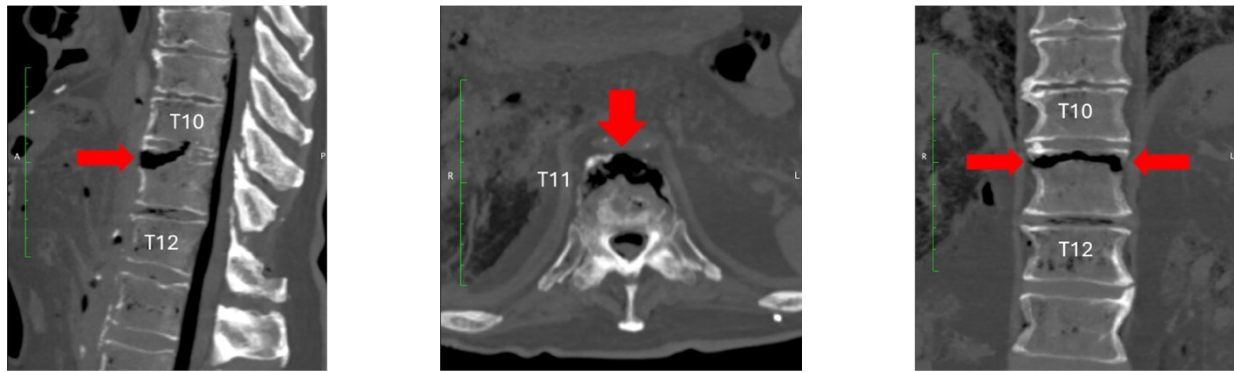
Exemplar CT scan of the lower thoracic spine (left = sagittal, middle = axial, right = coronal views) following the test revealing a fracture of the T11 vertebral body (red arrows).
